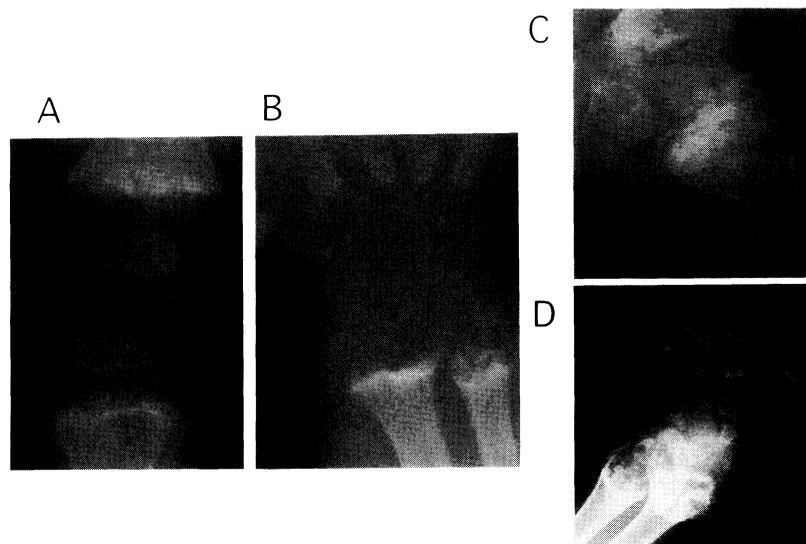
Bone radiographs during infancy (A · B) and at age 13 yr (C · D). The right knee (A) and left hand at age 3 mo (B), right femoral neck (C) and left hand at age 13 yr (D) are shown. At age 3 mo, there is irregularity of metaphyseal ends, cupping and cortical lucencies. The metacarpals have a permeative lucency with poor definition of the cortex suggestive of subperiosteal resorption. At age 13 yr, the femur is very short with bulging proximal and distal ends. There are many cyst-like areas in the bone radiographs (C · D).
